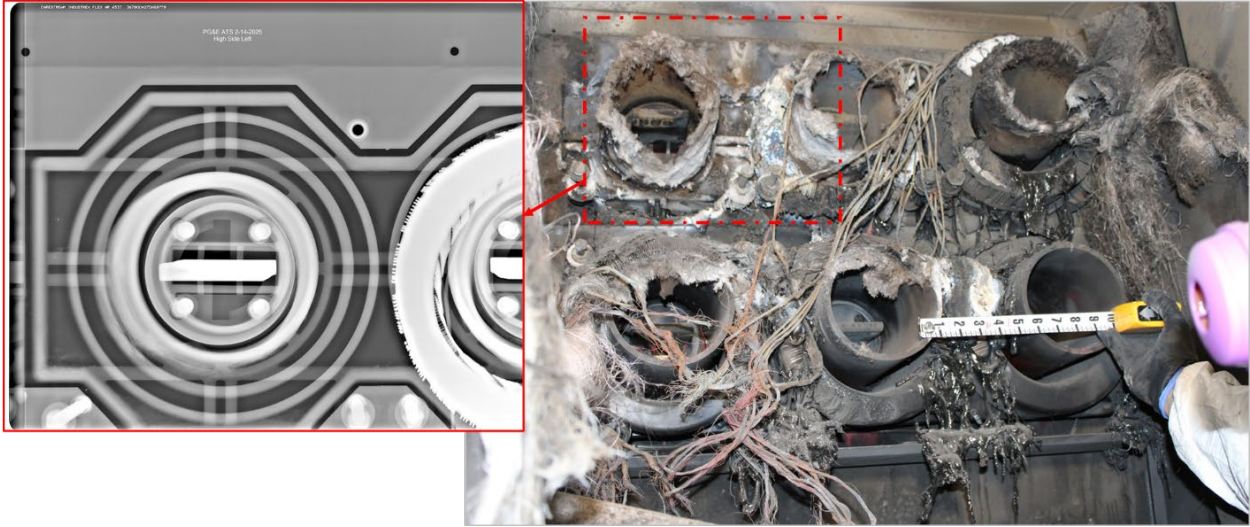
X-ray imaging at the back of the Incident Cubicle did not show evidence of metal erosion and arcing at the current transformers or the busbar tabs entering the cubicle.
